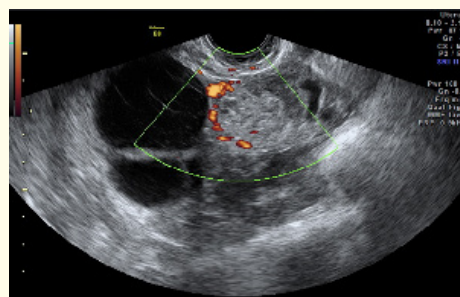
Ring of fire sign. Transvaginal Color-Doppler ultrasound image of tubal pregnancy with peripheral hypervascularity.
